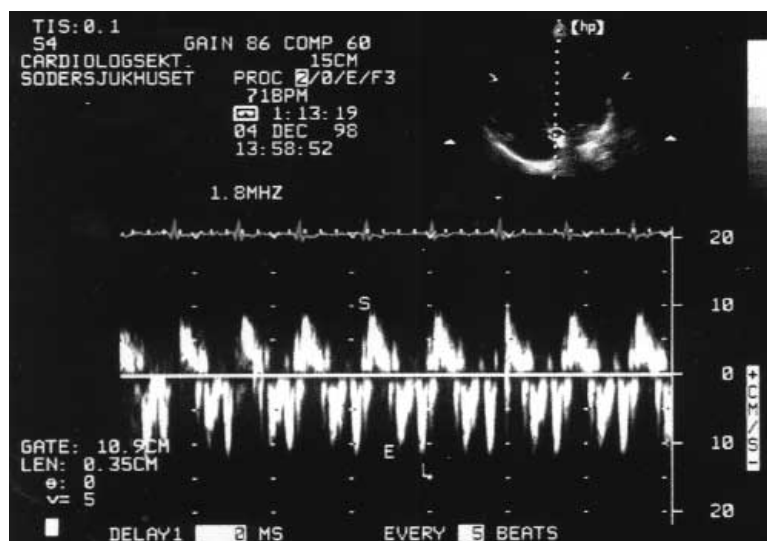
Two-dimensional apical 4-chamber view with the sample volume of the Doppler myocardial velocity recording at the septal border of the mitral annulus (*upper part of figure*). The systolic (S) and early (E) and late (L) diastolic velocities (cm/s) are shown in the *lower part* of the figure.
